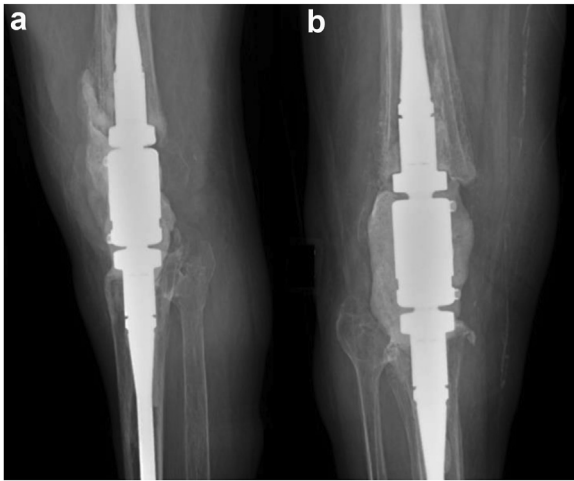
Second reoperation for a patient with superficial infection. Postoperative radiographs after removal of superficial antibiotic cement with retention of the modular knee arthrodesis (MKA).
